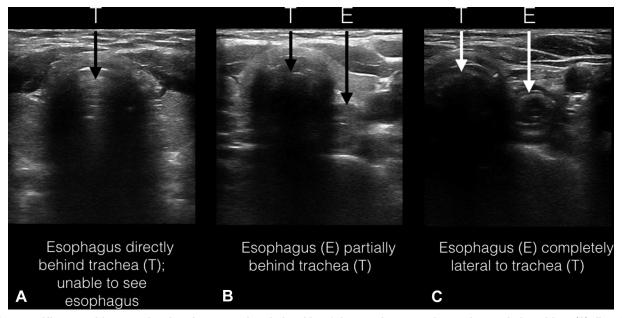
Ultrasound images showing the anatomic relationship of the esophagus to the trachea as being either: (A) directly behind the trachea, (B) partially behind the trachea, or (C) completely lateral to the trachea.
